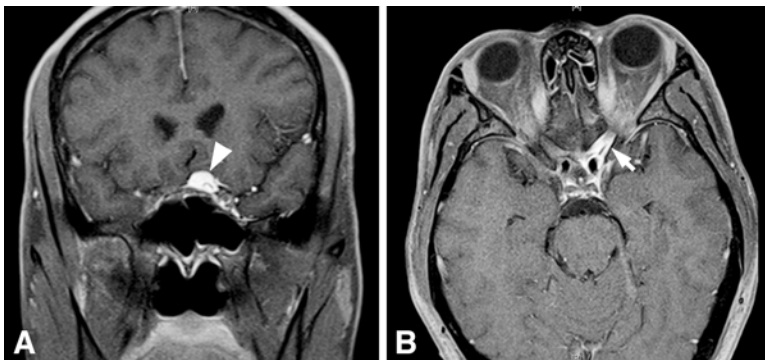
Six weeks after vision loss in the left eye. Contrasted T1 coronal (A) and axial (B) MRI shows enlargement of the suprasellar mass (arrowhead), the appearance of the left optic nerve (arrow) is unchanged.
